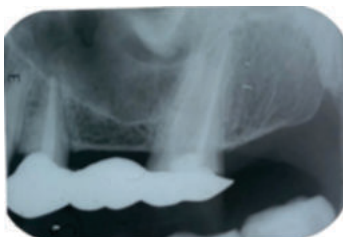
Intra-oral periapical radiograph ruling out odontogenic cause
